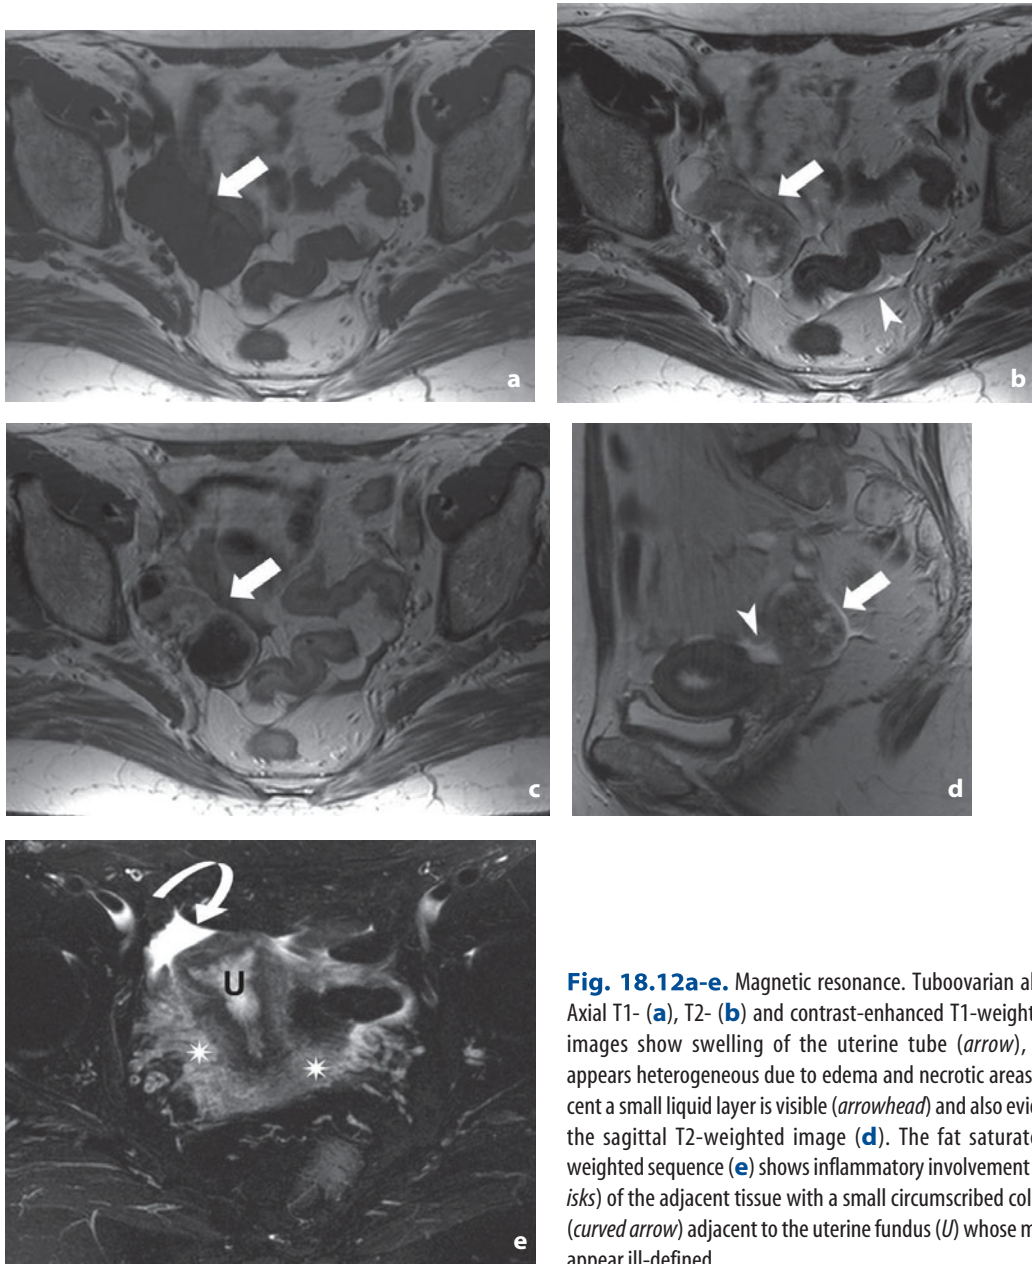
Magnetic resonance. Tuboovarian abscess. Axial T1- (a), T2- (b) and contrast-enhanced T1-weighted (c) images show swelling of the uterine tube (*arrow*), which appears heterogeneous due to edema and necrotic areas. Adjacent a small liquid layer is visible (*arrowhead*) and also evident in the sagittal T2-weighted image (d). The fat saturated T2-weighted sequence (e) shows inflammatory involvement (*asterisks*) of the adjacent tissue with a small circumscribed collection (*curved arrow*) adjacent to the uterine fundus (*U*) whose margins appear ill-defined
